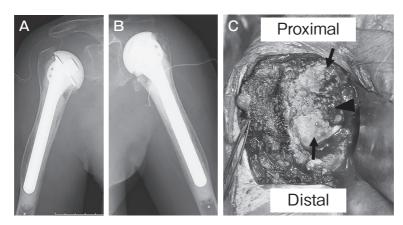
Postoperative radiographs of the right (A) and left shoulder hemiarthroplasties (B). Each component was inserted with bone cement. C: Intraoperative findings from the right shoulder hemiarthroplasty. The humeral head was diffusely damaged (*black arrowhead*), and the remaining articular surface had degenerated (*black arrows*). No synovitis was detected.
